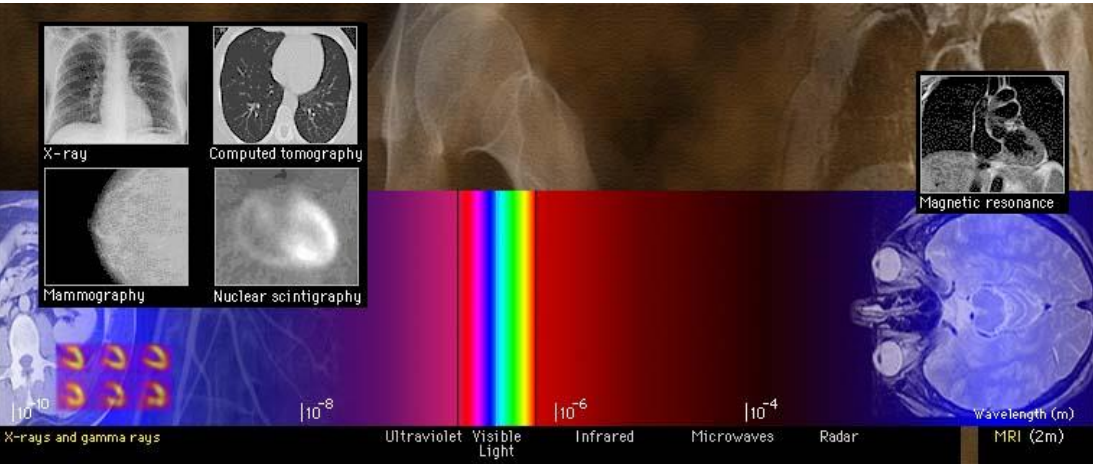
Ionizing (X-ray, computed tomography, mammography, nuclear scintigraphy) and non-ionizing (magnetic resonance) imaging (Url-1, 2015).
